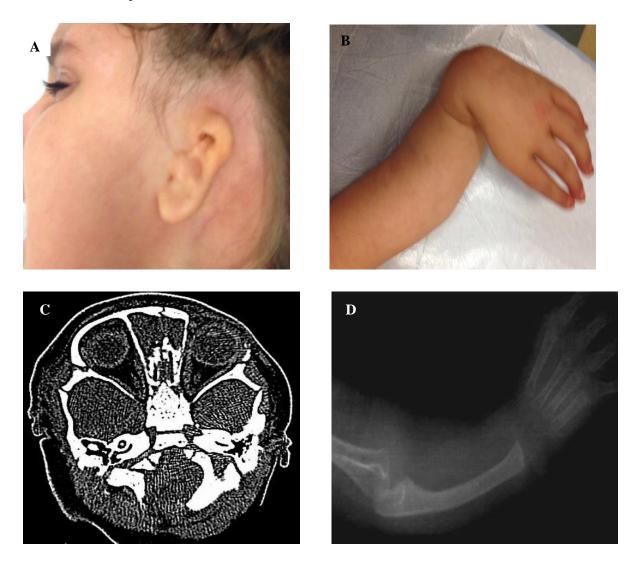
Displastic auricula (A), absence of thumb, bowing of short ulna, flexion deformity of hands (B), temporal CT shows closed external auditory canal (C) X-rays of upper limbs showing absence of radii and thumb (D).
